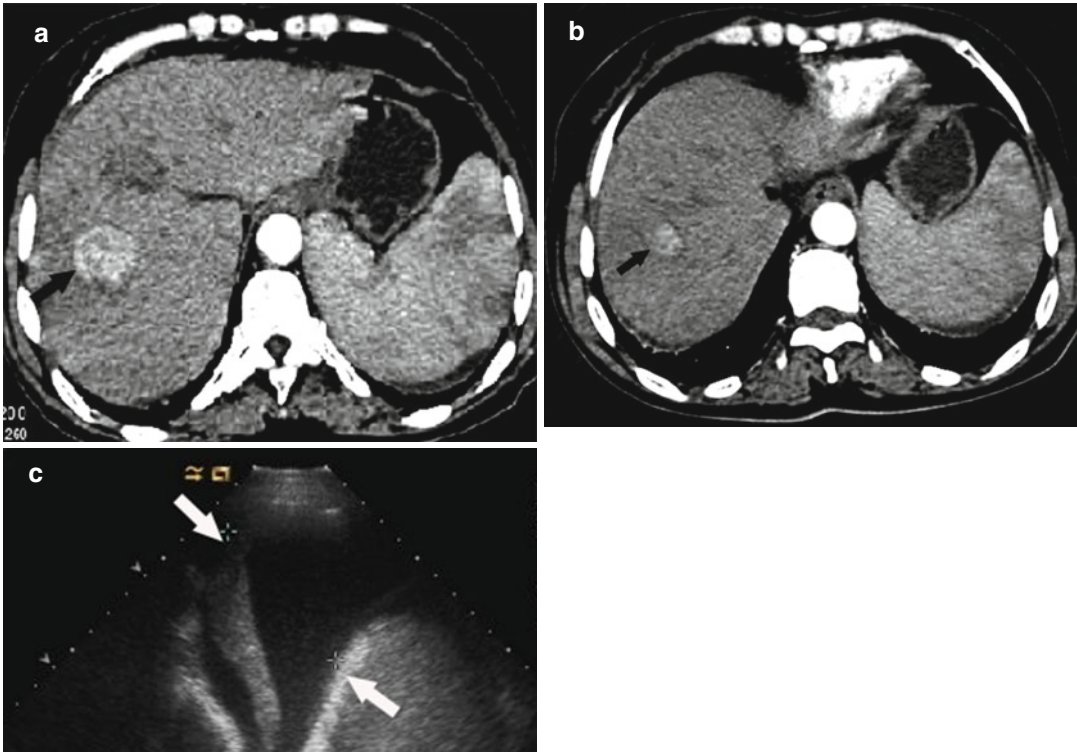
Pleural effusion in a 61-year-old female patient with primary hepatocellular carcinoma with the size of 3.1×3.0 cm. (a) Preoperative CT showed a marked enhancement of mass in segment 7 close to the diaphragm
